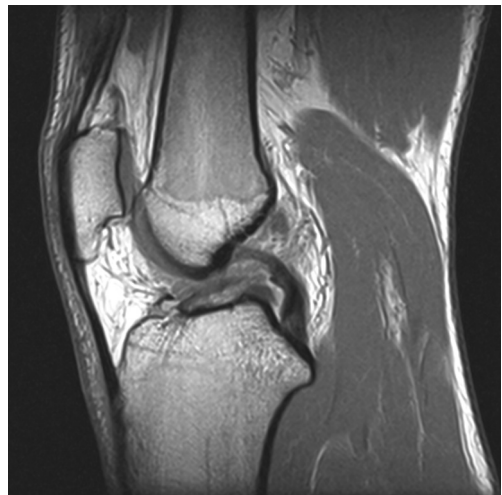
Magnetic resonance imaging of an anterior cruciate ligament rupture.
